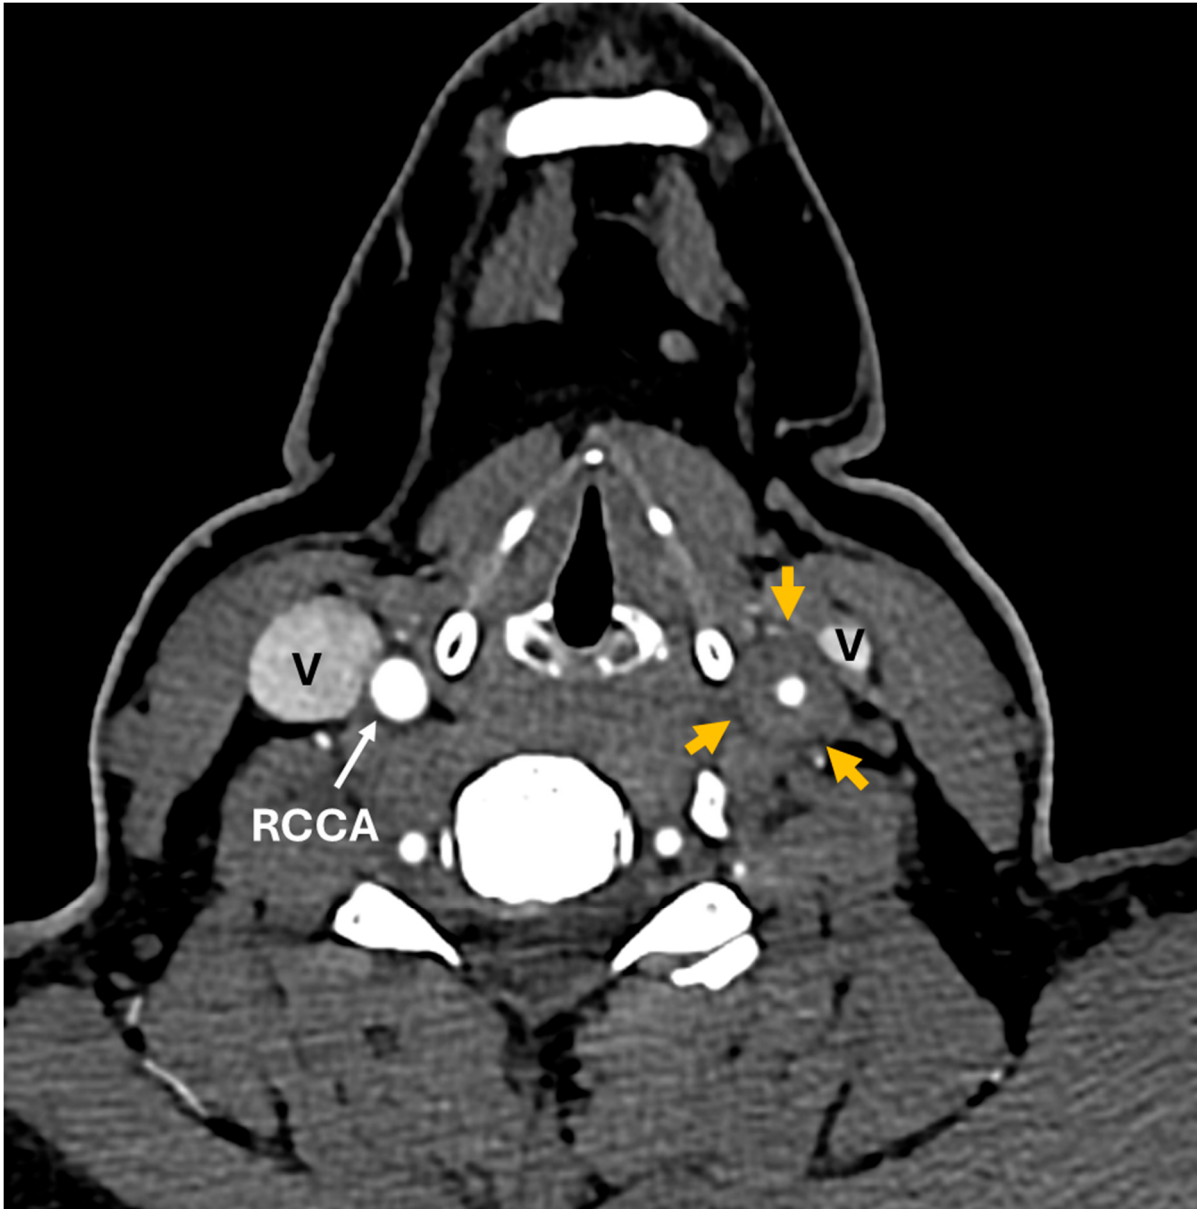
CT angiogram, axial images below the level of carotid bifurcation shows diffuse circumferential thickening of the common (CCA) and internal carotid artery (ICA) wall on the left side (orange arrows).
